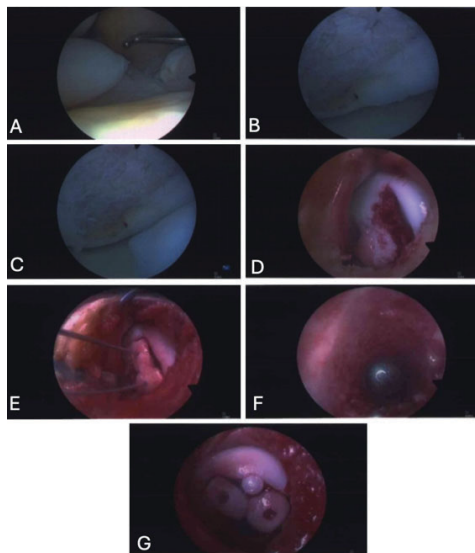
Intraoperative images, acquired with the arthroscopy camera. (A) Loose body demonstrated. (B and C) Osteochondral lesion in the medial femoral condyle. (D) Image taken of the whole extent of the osteochondral defect in the medial femoral condyle with a small open approach to the medial femoral condyle. (E) Pinning of the two loose bodies, before inserting headless compression screws to hold them in place. (F) Image taken from within the donor site of the osteochondral autograft transfer (OATS) to prove no physis was taken from the donor site (also confirmed with intraoperative radiography). (G) Final intraoperative image, demonstrating the two loose bodies, secured using headless compression screws, and the OATS.
